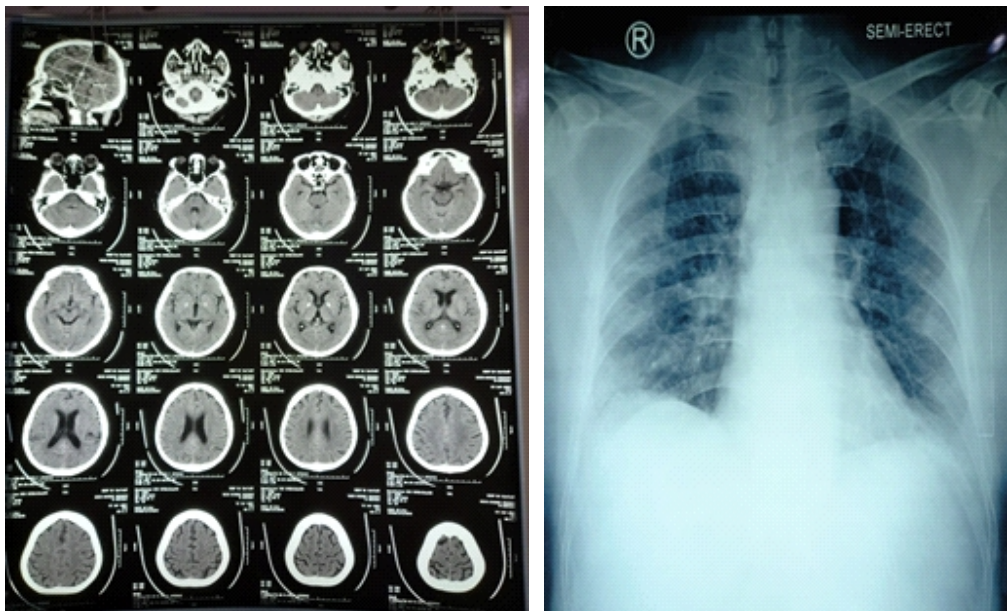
Head CT Scan results and Ro Thorax Case 2
